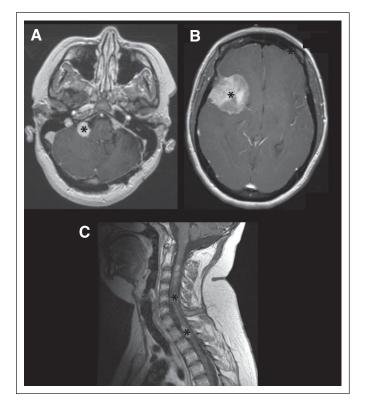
CNS tumors in neurofibromatosis type 2. (A) Bilateral vestibular schwannomas with gadolinium contrast enhancement (asterisk). (B) A large meningioma in the right anterior and middle cranial fossa in the axial plane (asterisk). (C) Multiple spinal cord ependymomas (string of pearls) in the sagittal T1-weighted contrast-enhanced magnetic resonance image of the cervical spine (asterisks).
